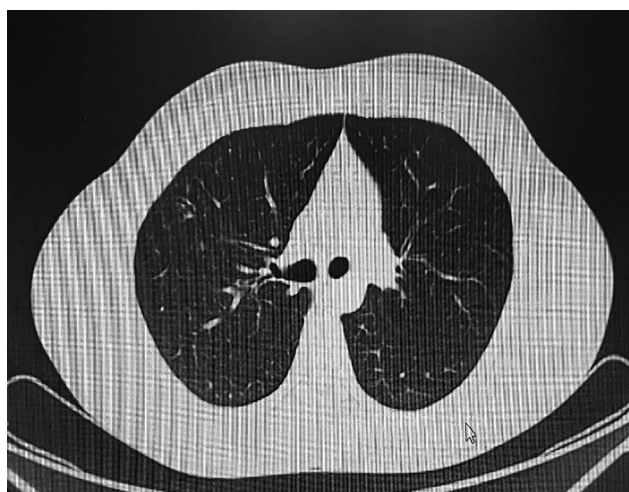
Control CT in the 4th month of treatment – a discrete fibrotic focus is observed in the right upper lung. There are no CT findings for focal and nodular lesions in the pulmonary parenchyma.
